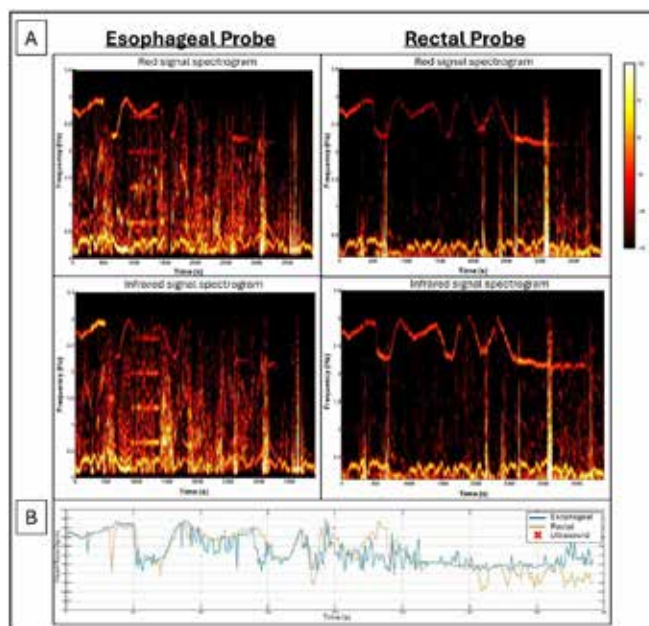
(A) Spectrogram plots of red and infrared signals comparing esophageal and rectal probes and resulting continuous heart rate plots. Spectrogram plots of the esophageal probe demonstrate larger background signal compared to rectal probe. However, there is still a discernable frequency plot for both red and infrared wavelengths in both esophageal and rectal probes. (B) Comparison of esophageal versus rectal heart rates demonstrate concordance with each other and in comparison to ultrasound reference.
